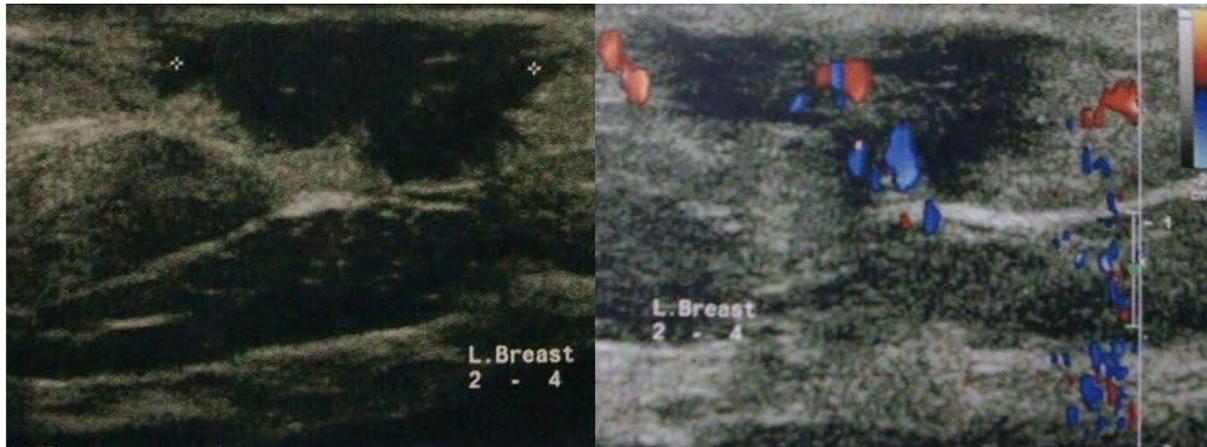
Ultrasound examination shows the presence of a solid, hypoechoic, lobulated mass in the upper external quadrant of the left breast, with internal flow on colour Doppler image.
